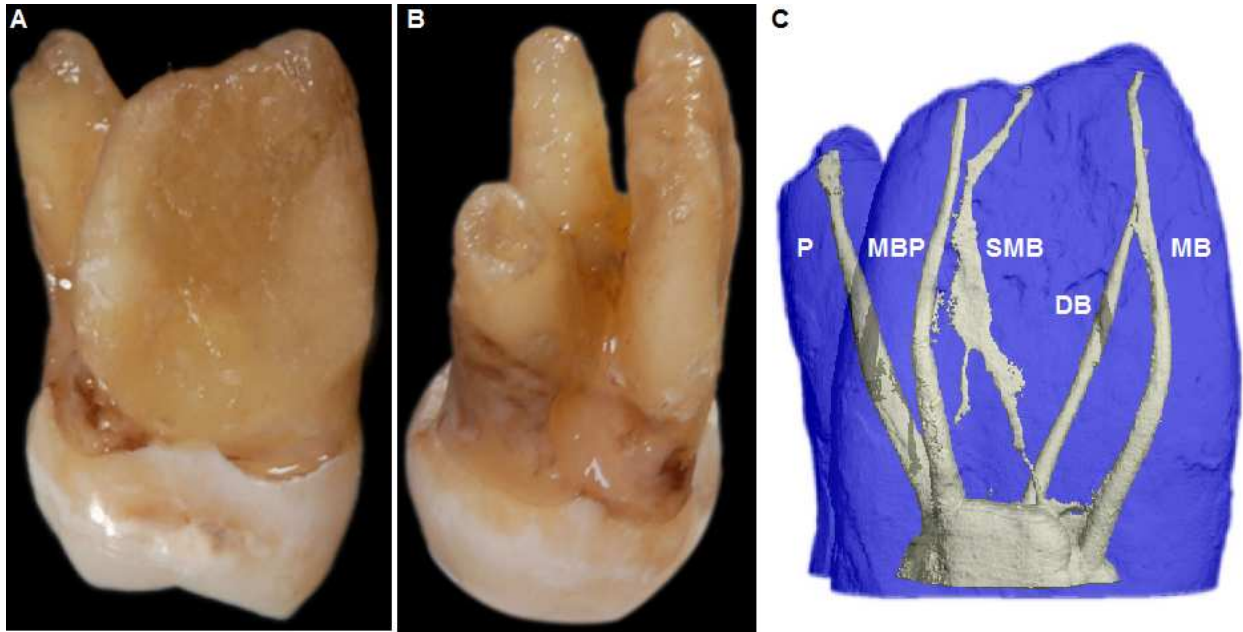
(A) A photograph of a three-rooted maxillary right molar showing a wide bucco-lingual dimension of MBR that obscure the distobuccal root. (B) A palatal view showing the three roots. (C) A μ -CT of the same tooth showing type VIII root canal configuration in the MBR (μ -CT was kindly performed by Dr. Frank Paqué).
